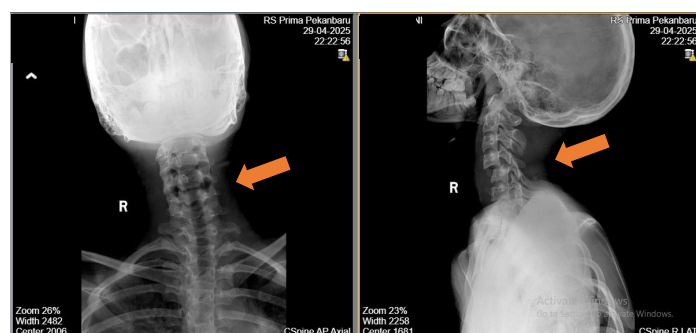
Cervical AP + Lateral X-Ray showed posterior dislocation of vertebrae C5 toward C4
